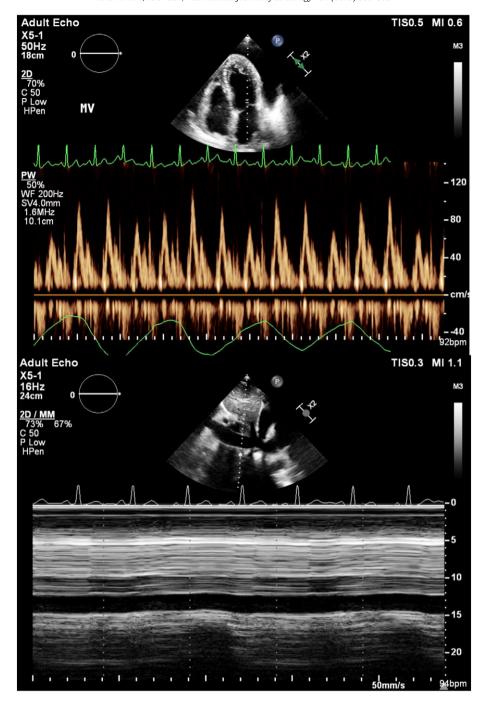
Transthoracic echocardiogram. Respirophasic variation in mitral valve inflow and plethoric inferior vena cava, without inspiratory collapse.
